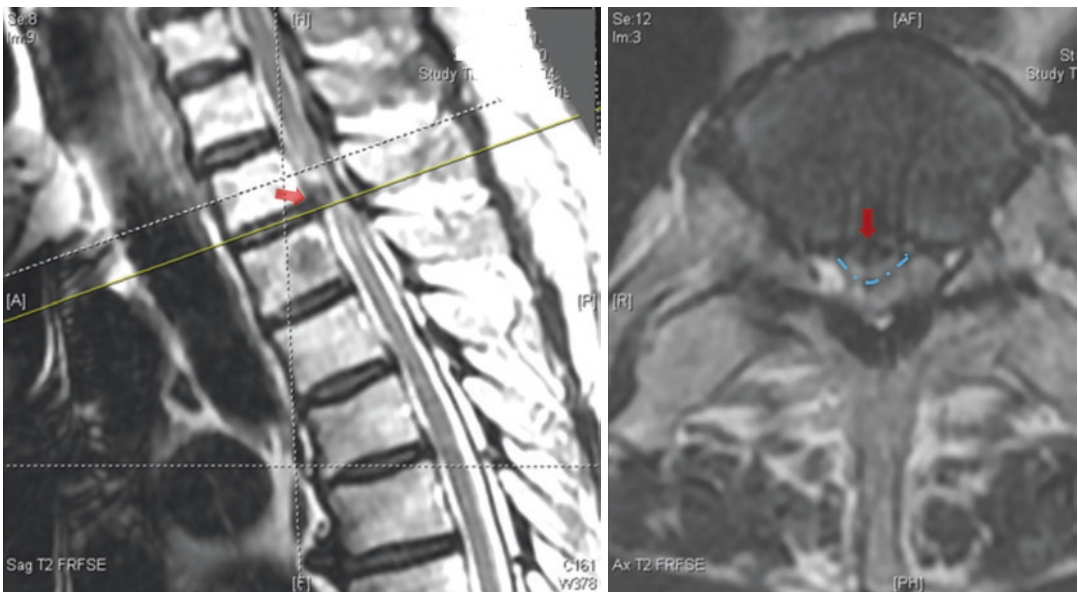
The preoperative MRI showed a right paramedian TDH combined with dural hypertrophic ligamentum flavum. (Red arrow: herniated disc; blue dotted line: margin of herniated disc)
